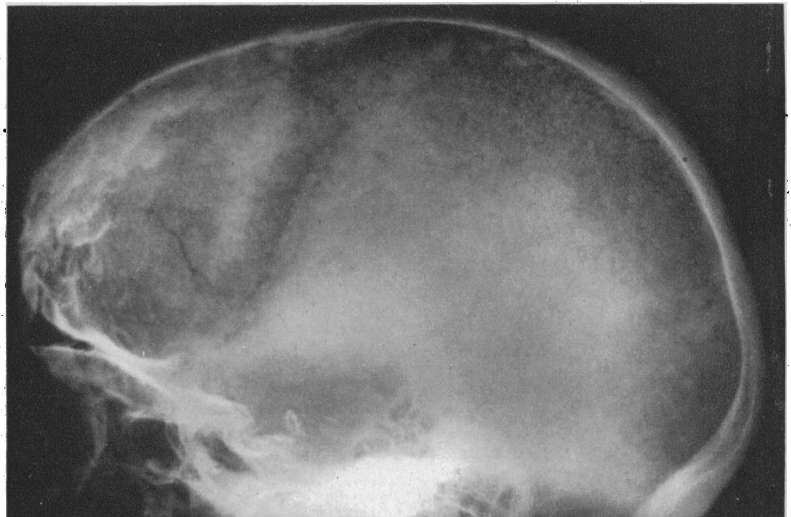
Lateral radiograph of skull showing hyperostosis on internal surface of frontal bone and calcification of base of pituitary fossa. The frontal sinuses are large and the mastoids over-pneumatized.
